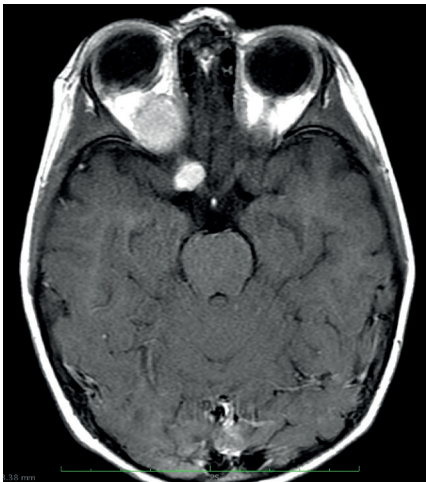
Axial T1-Weighted Contrast of MRI of the brain shows dumbbelled shape of tumor extends intra-orbital and intra-cranial
